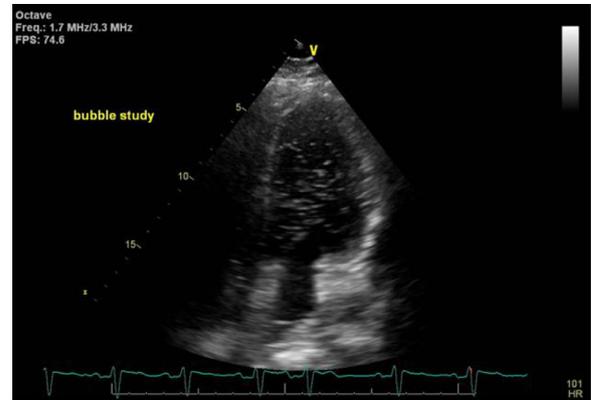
Transthoracic echocardiography bubble study demonstrating the presence of saline contrast (bubbles) in the left ventricle, diagnostic of a right-to-left intracardiac shunt through a patent foramen ovale.
